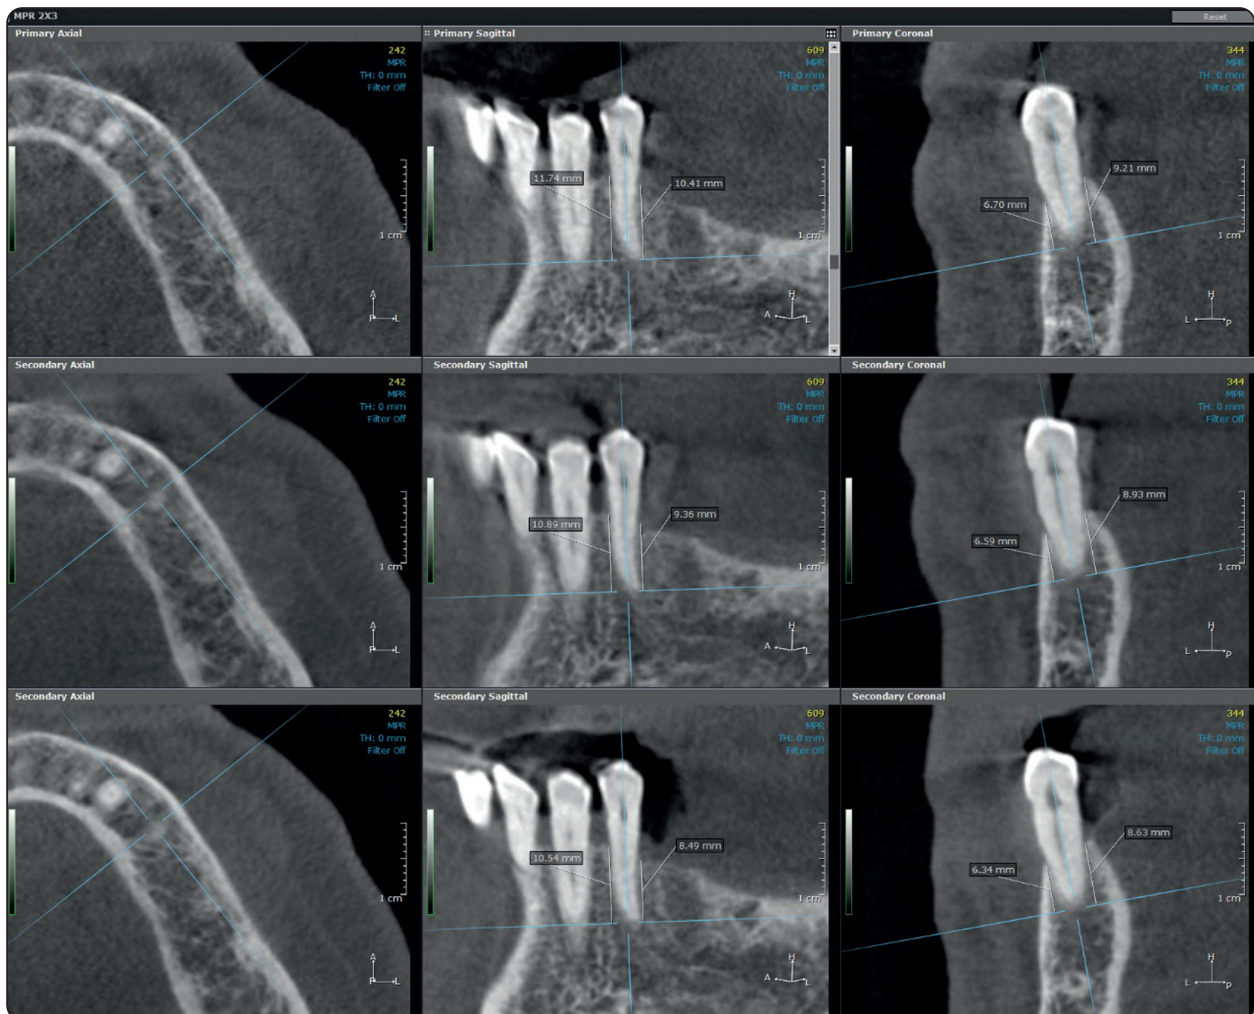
Evaluation of alveolar bone loss around abutments using cbct scan
